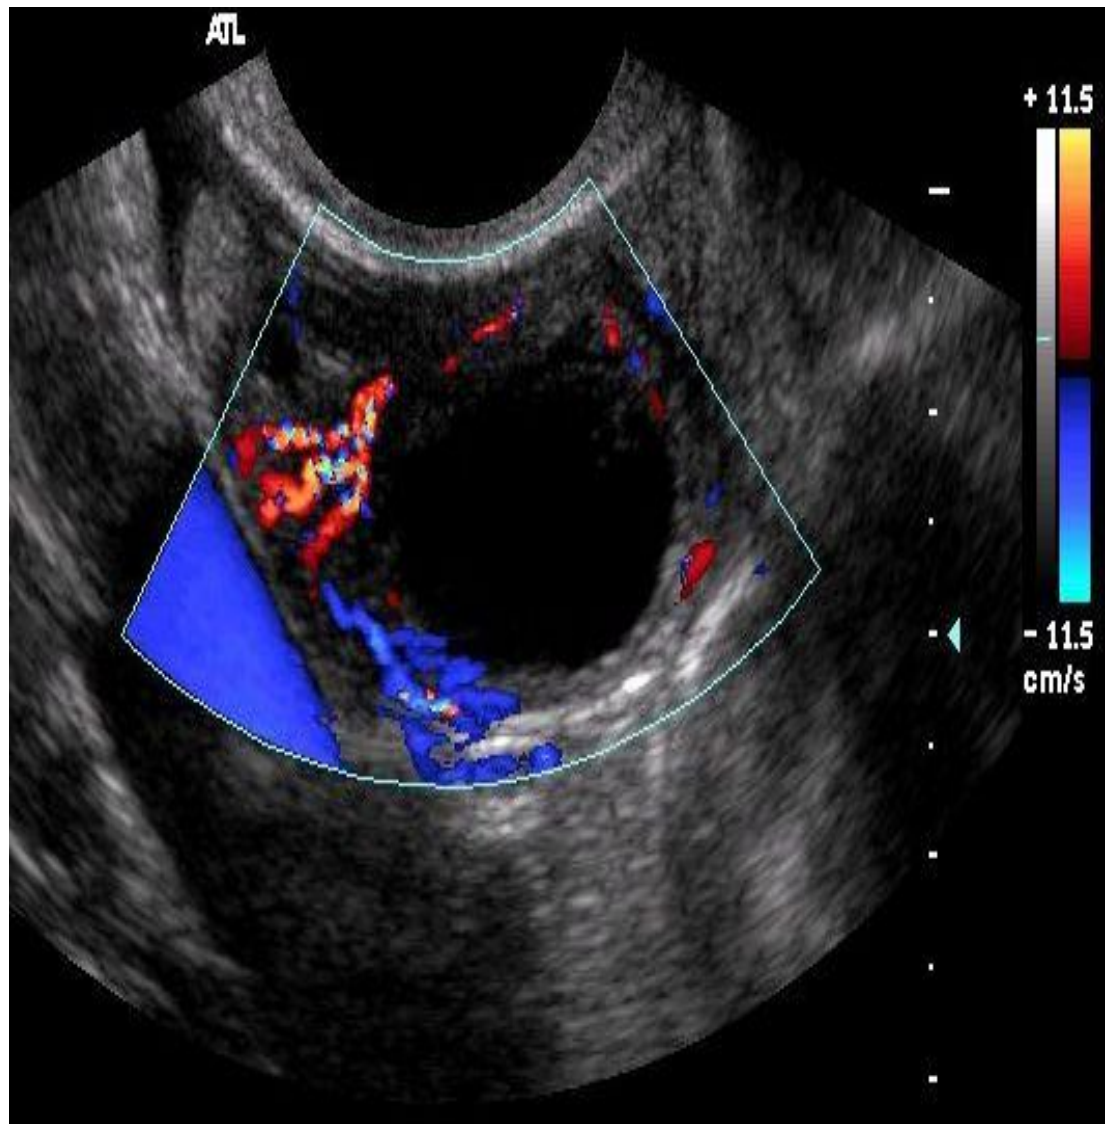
b .shows colour Doppler image of malignant tumour with increased flow
